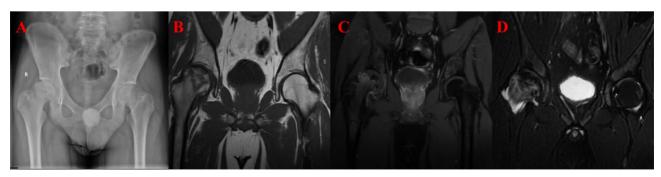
Representative case of a 16.5-year-old boy at the initial GC treatment who underwent one iv methylprednisolone pulse treatment due to HSPN (cumulative dose 2.25 g), followed by continuous po prednisone (cumulative dose 9.4975 g). After 0.83 years of continuous GC treatment (cumulative GC dose 15.635 g), the patient underwent imaging examinations due to right hip pain and was diagnosed with bilateral SONFH. (A) Radiograph shows that the right femoral head is slightly flatter than the left side, and uneven densities of the femoral head and neck are visible. (B, C) Uneven signals are observed in the right femoral head, mainly long T1 and T2 signal changes. (D) Obvious heterogeneous enhancement of the femoral head is visible, indicating avascular necrosis.
